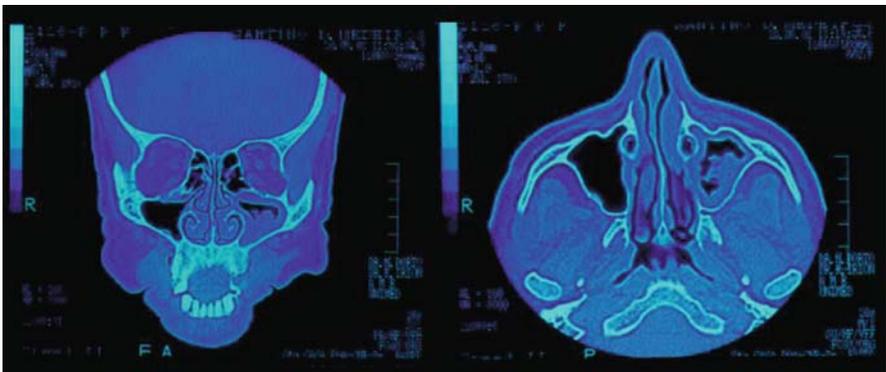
A computed tomography scan showing partial opacification of the left maxillary sinus along with thickening of the sinus mucosa with irregular soft tissue mass, with anfractous contours of a fungal ball due to *S. apiospermum*
